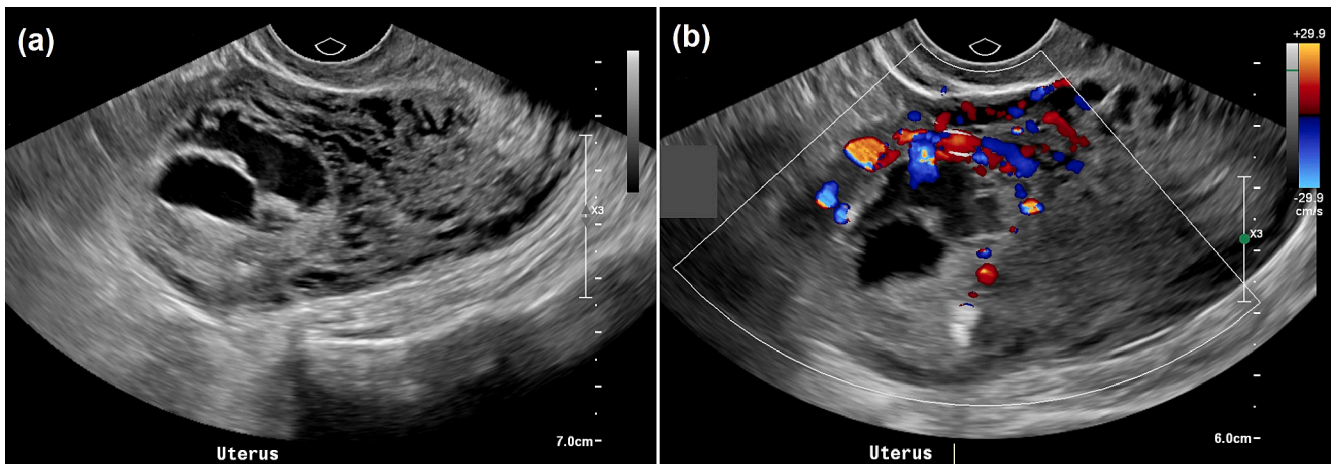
(a) Transvaginal ultrasound of the uterus demonstrating irregular cystic spaces in the anterior myometrium. (b) The surrounding areas are hypervascular on colour Doppler.
